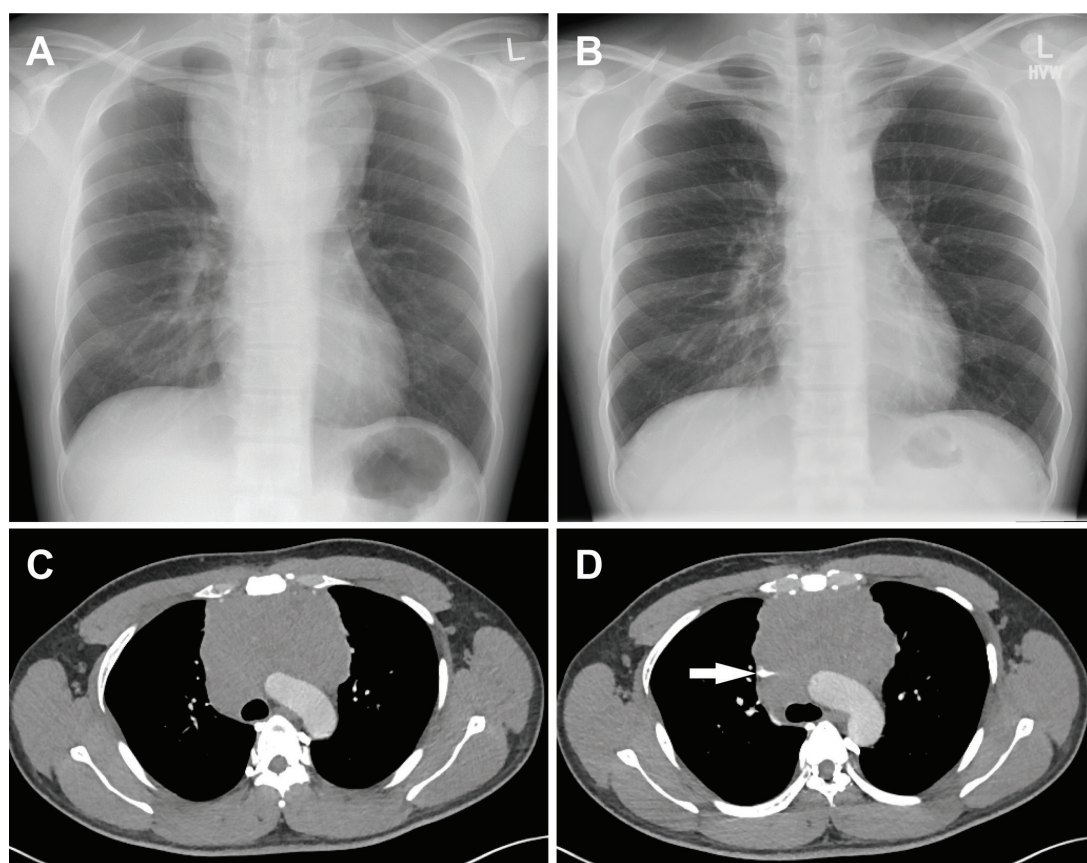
(A) Chest radiograph at presentation demonstrating a large upper mediastinal mass. (B) Chest radiograph 18 days later showing a dramatic reduction in size of the mediastinal mass. (C) Contrast-enhanced CT imaging of thorax showing a slice 15 mm superior to that in D, demonstrating complete SVC occlusion (absence of visible contrast medium). SVC, superior vena cava. (D) Contrast-enhanced CT imaging of the thorax demonstrating contrast medium in SVC (see arrow), which is compressed by an anterior mediastinal mass.
